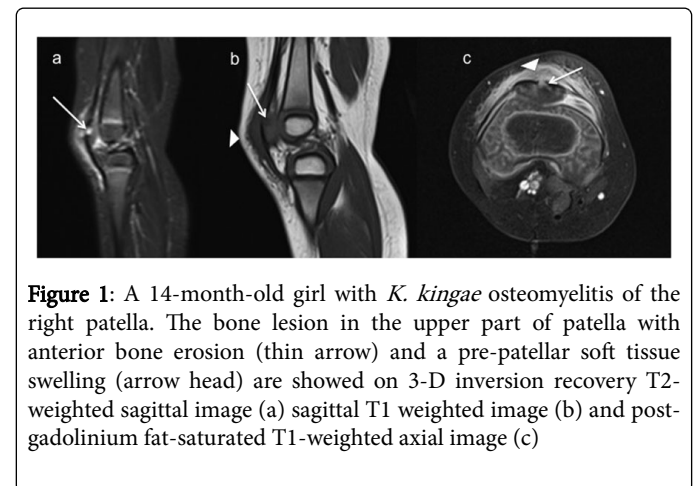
A 14-month-old girl with *K. kingae* osteomyelitis of the right patella. The bone lesion in the upper part of patella with anterior bone erosion (thin arrow) and a pre-patellar soft tissue swelling (arrow head) are showed on 3-D inversion recovery T2-weighted sagittal image (a) sagittal T1 weighted image (b) and post-gadolinium fat-saturated T1-weighted axial image (c)
